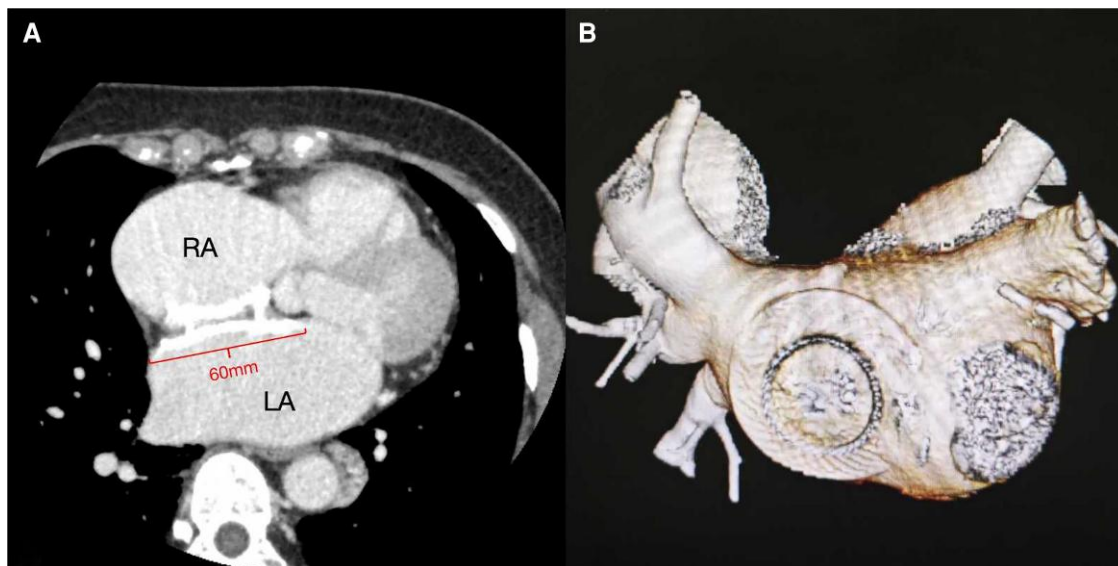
CT angiography of the LA. (A) Cross-sectional view showing the ASD occluder reaching the edge of the atrial septum; (B) Reconstruction model of the left atrium showing that the closure device occupied the entire atrial septum surface. ASD, atrial septal defect; RA, right atrium; LA, left atrium.
